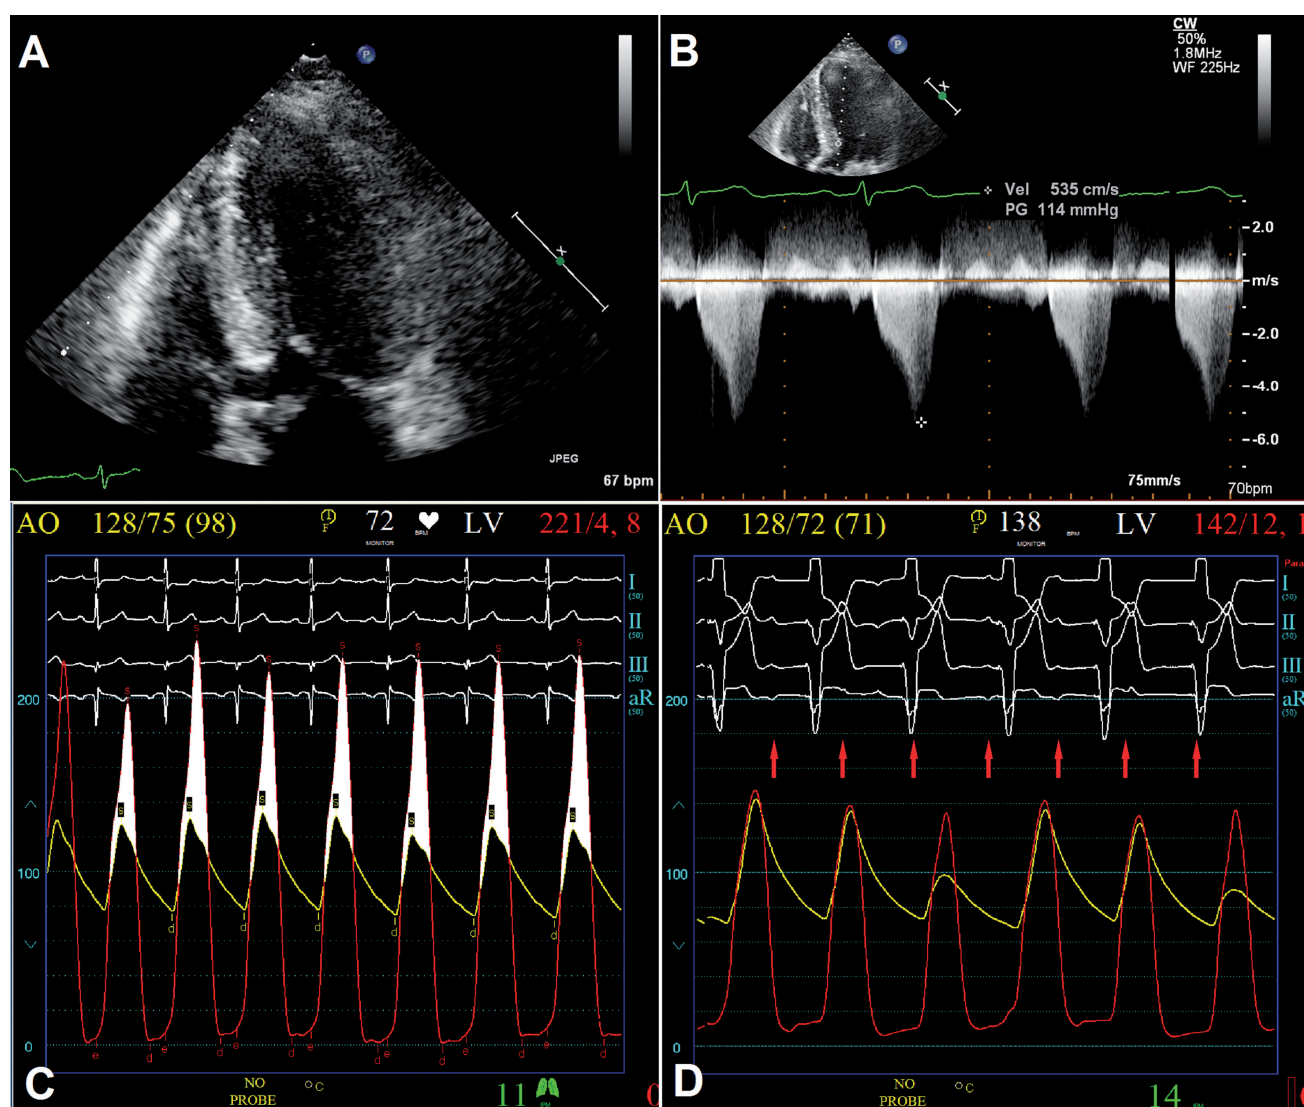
Transthoracic echocardiography prior to ASA revealed septal hypertrophy and systolic anterior motion of the mitral valve (A); A resting LVOG of 114 mmHg detected with Doppler echocardiography (B); A hemodynamic study confirmed LVOG of 141 mmHg (C); After ASA a transient complete heart block occurred with varying LVOG due to AV dyssynchrony, P waves are indicated with arrows (D).
